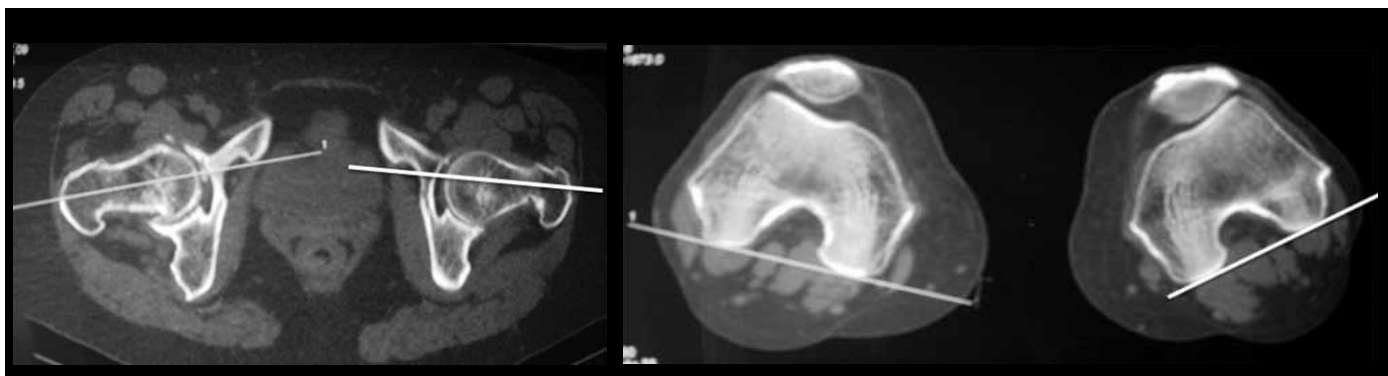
Computed tomography of the coxofemoral joint and bilateral femoral condyle, with the respective measures.
